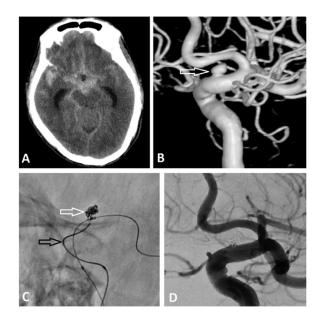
(A) Diffuse subarachnoid hemorrhage on computed tomography image pre-intervention. (B) 3-dimensional digital subtraction angiography (3D-DSA) image showing a blister-like aneurysm arising from the right supraclinoid ICA (arrow). (C) Image obtained following coil deposition (white arrow) with balloon assistance (black arrow). (D) DSA image after intervention demonstrating complete aneurysm occlusion.
